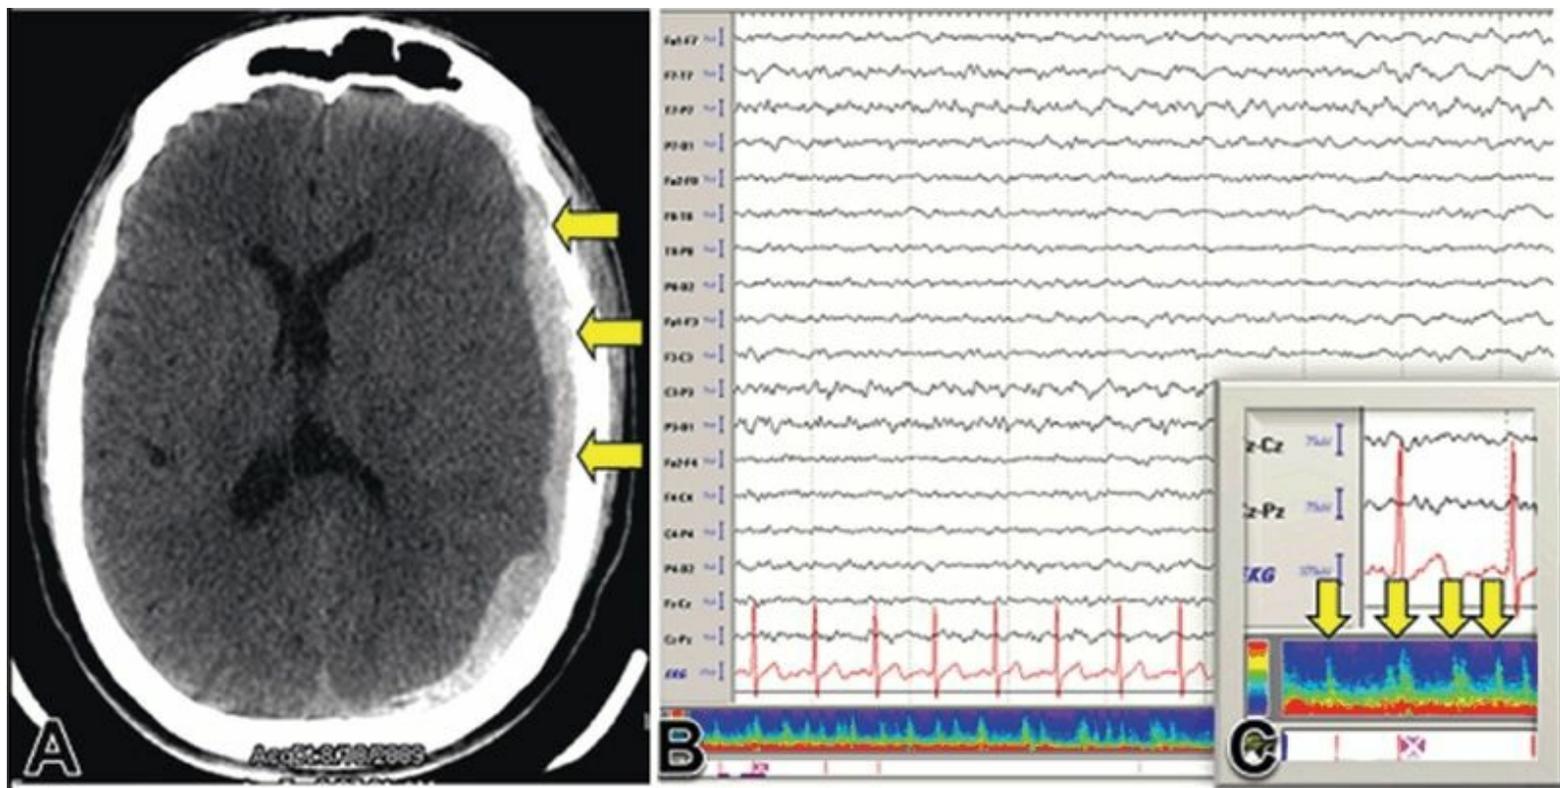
A: Patient who presented with altered mental status and headache with a CT brain showing a left hemisphere subdural hematoma with midline shift (arrows). B: EEG of this patient showing left hemisphere seizure pattern that is slowly evolving in frequency. C: Expansion of the DSA trend analysis showing multiple seizures in the record (arrows).
